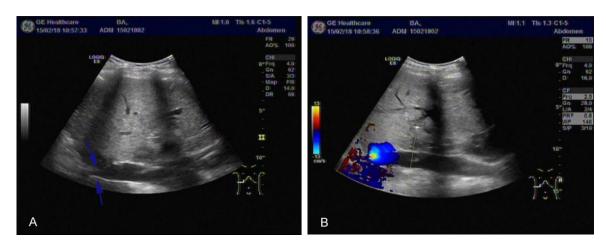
Postcava complications. A. The ultrasonogram showed anastomotic stenosis (arrow) with an inner diameter less than 0.7 cm in 51-year-old female patient; B. The upstream postcava lumen was broaded.
